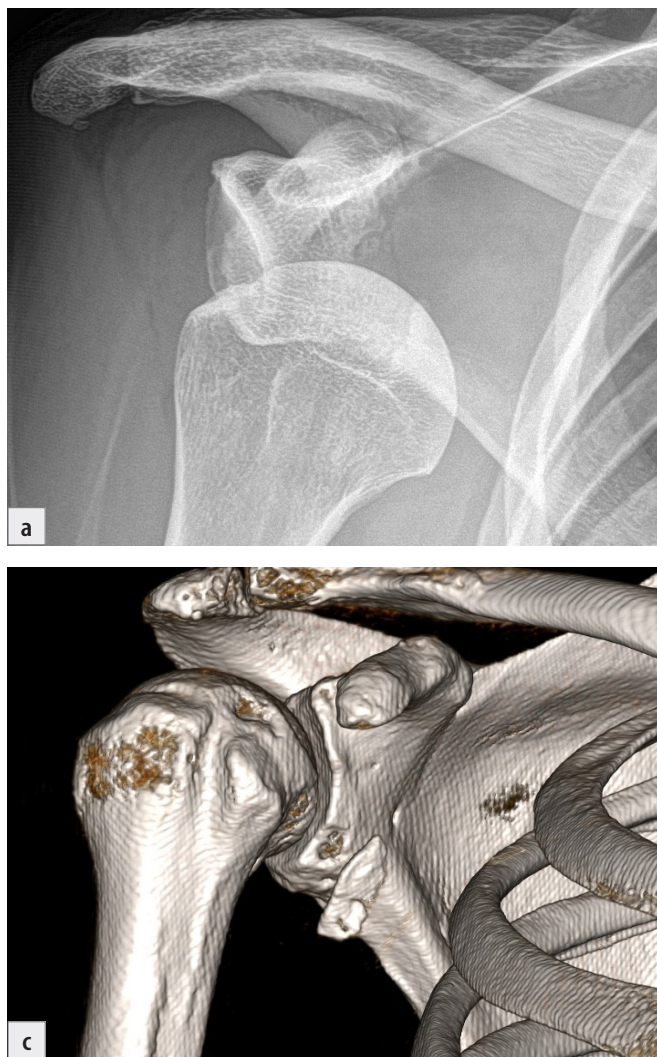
Glenoid fracture with the arm abducted horizontally. The humeral head is driven against the central part of the glenoid, its impact results in avulsion of the anterior rim of the glenoid and coracoid process: a) anterior view; b) CT transverse scan; c) superior-anterior view; d) lateral view.
